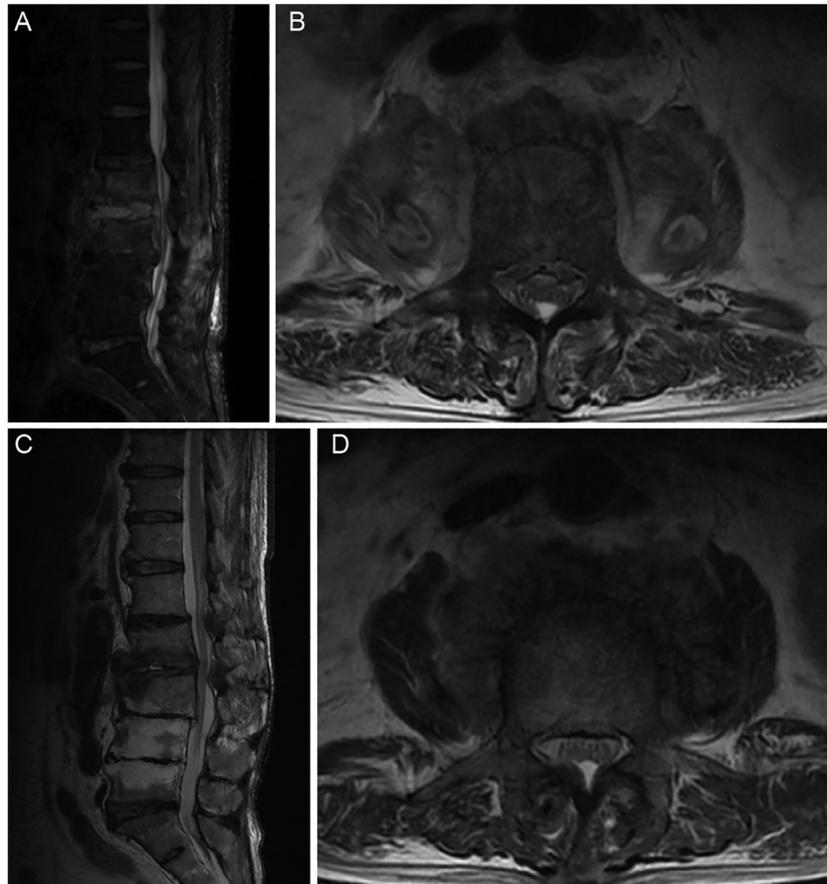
An 80-year-old man (Patient 4) had severe low back pain and right leg pain. His associated medical illness was breast cancer treated with chemotherapy. The causative organism was methicillin-sensitive *Staphylococcus aureus*. T2 sagittal (A) and axial (B) MR images demonstrated L2–L3 vertebral bony destruction and abnormal intervertebral disc signal changes with epidural and iliopsoas mass formation. Percutaneous suction aspiration and drainage (PSAD) was performed, and the inflow tube was retained after PSAD for 14 days, and the outflow tube was retained for 15 days. Laminectomy was not performed. His low back pain and leg pain decreased immediately after PSAD, and MRI showed that the epidural and iliopsoas abscesses disappeared at 12 weeks postoperatively (C, D).
